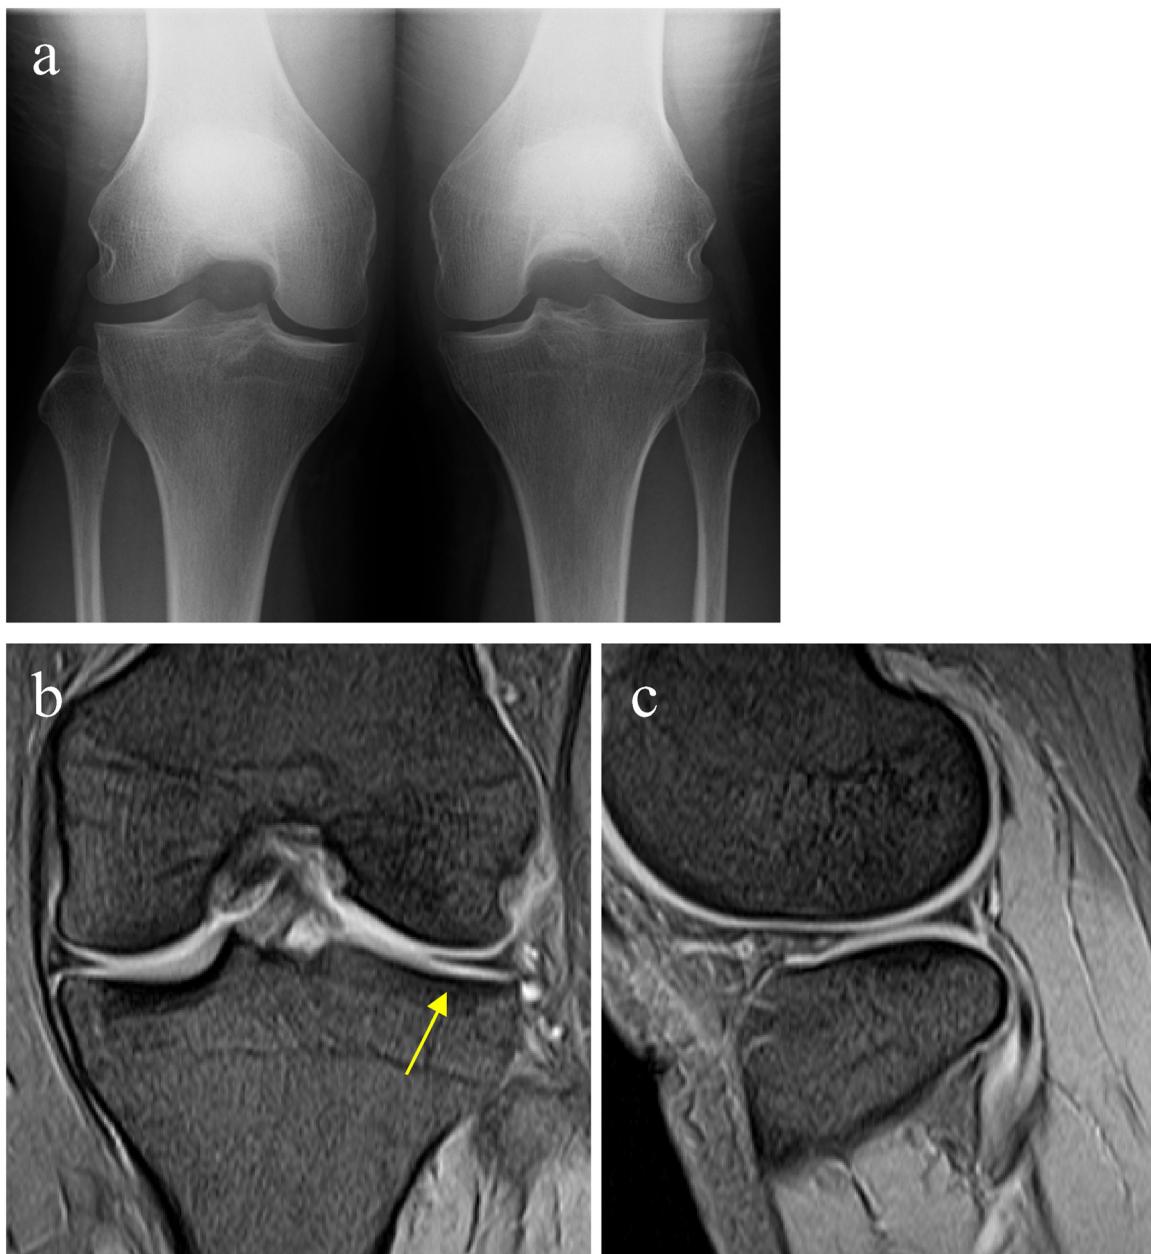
Postoperative images of the first case at 2 years after the surgery. Rosenberg-view (a). Mid-coronal (b) and mid-sagittal (c) T2-weighted MRI images.
